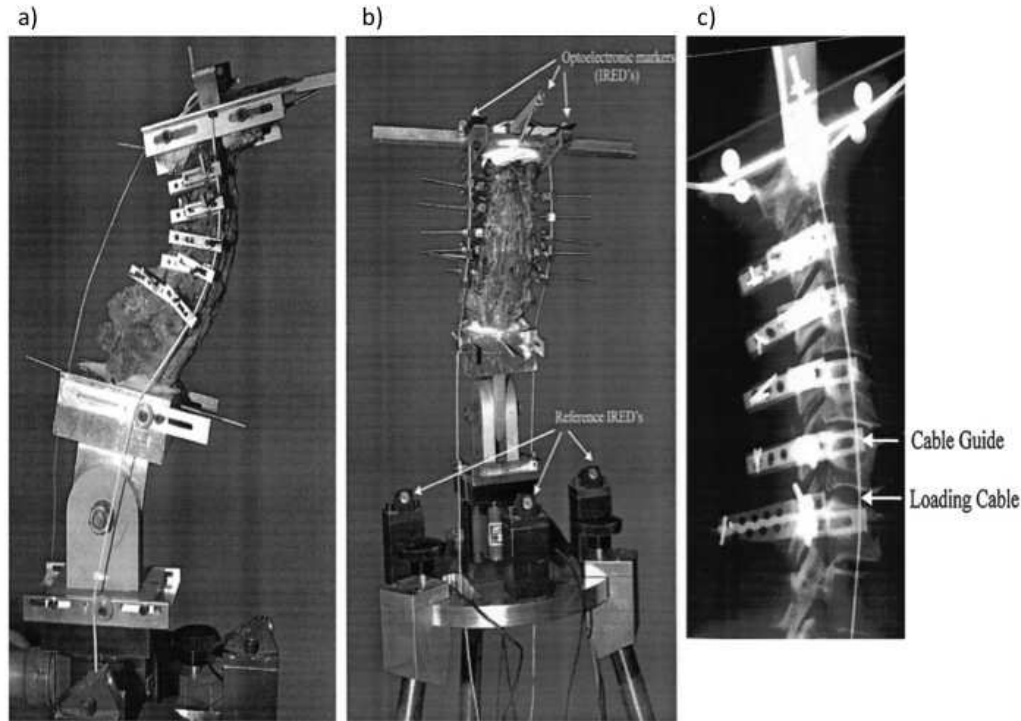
A human cervical spine (C2-T2) subjected to a compressive follower load: a) Lateral view of novel fixture, b) Front view of novel fixture, c) Lateral x-ray of follower load highlighting cable guiding mechanism. The citation for the source image can be found in Appendix B.
